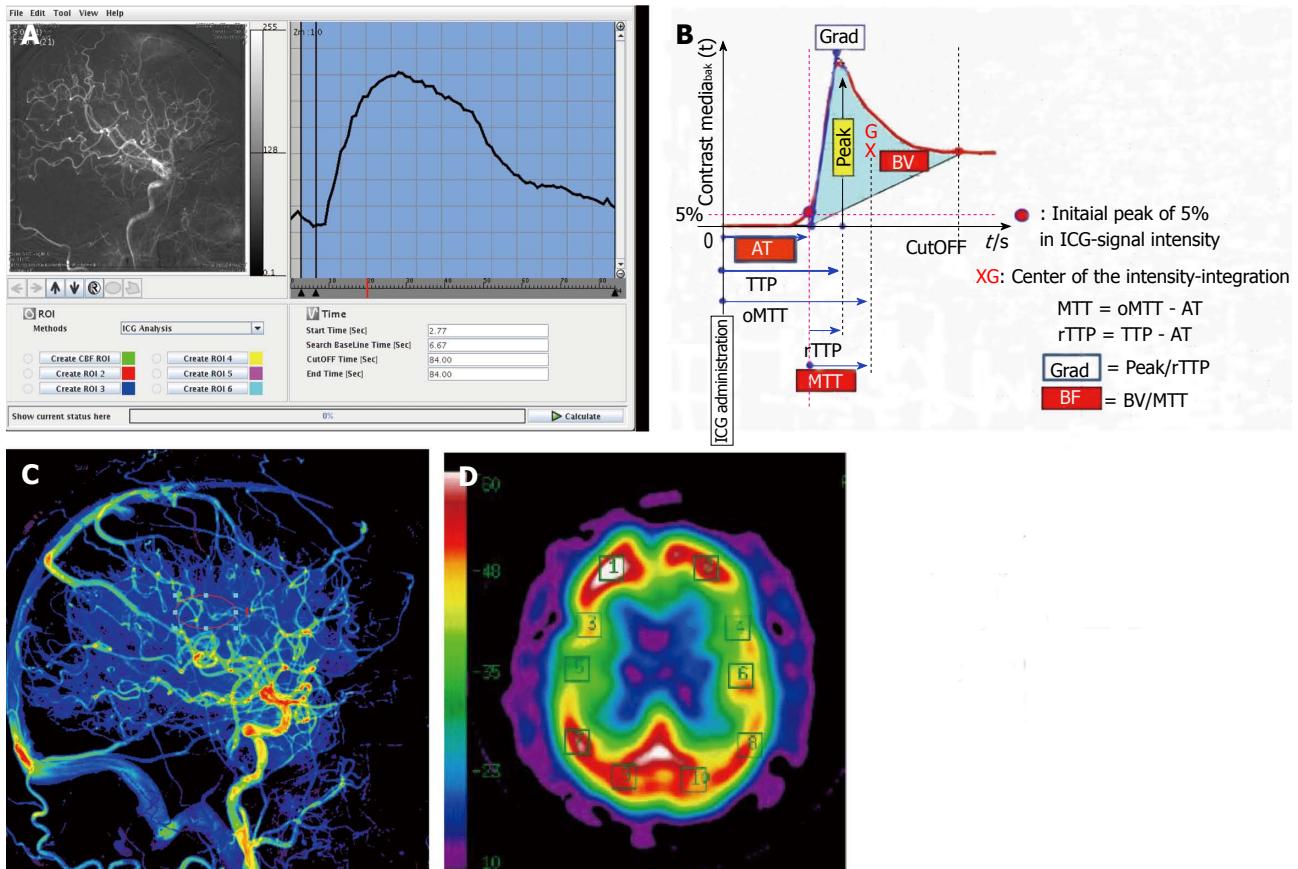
Digital subtraction angiography. A: Time-density curve of digital subtraction angiography lateral view. The change in the concentration of the contrast media, visualized as a change in brightness, was calculated; B: The parameters calculable by the "Flow-Insight" application; C: Lateral view of a pre-operative qualitative image of cerebral blood flow in Case 2; D: Pre-operative N-isopropyl-p-[123I] iodoamphetamine-single-photon emission computed tomography image.
